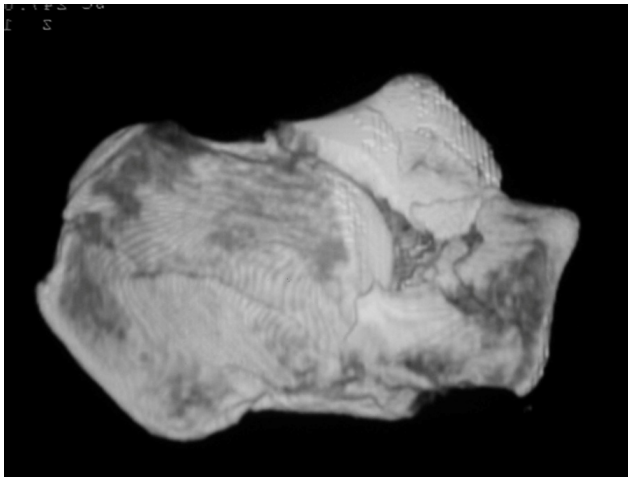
3D-CT showing a case of the combined form:
